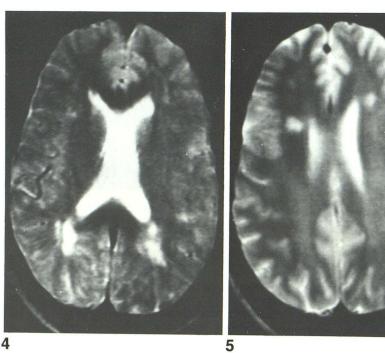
Representative MR image of patient 1 shows increased signal intensity in periventricular white matter (TE = 70, TR = 3960).
